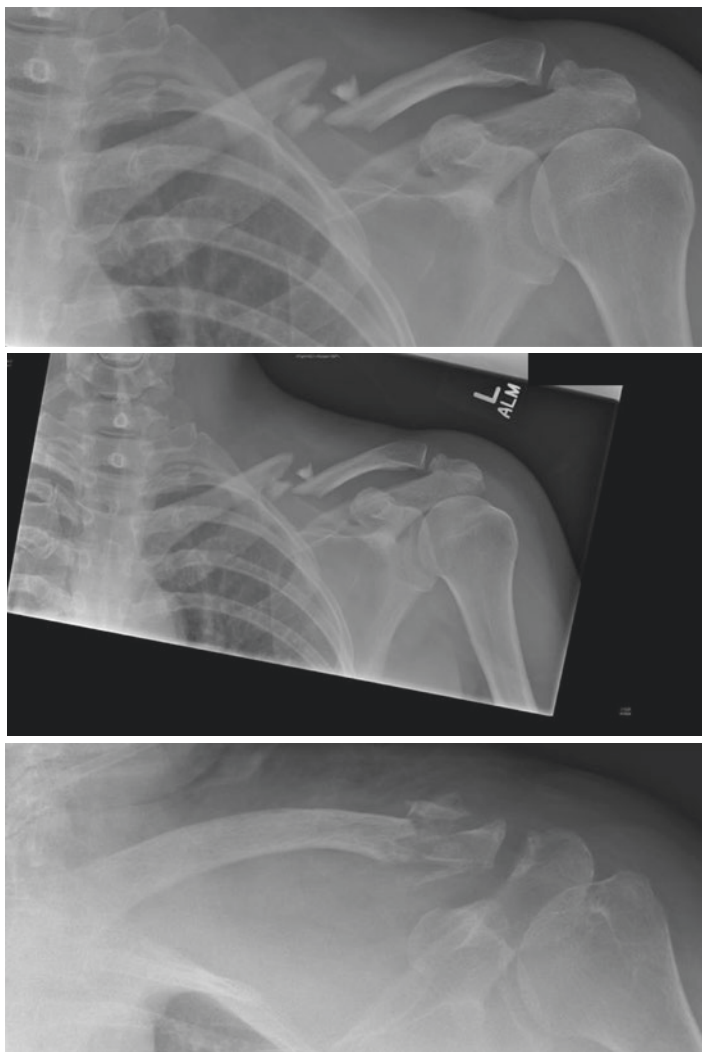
Radiographs of middle and lateral third clavicle fractures
